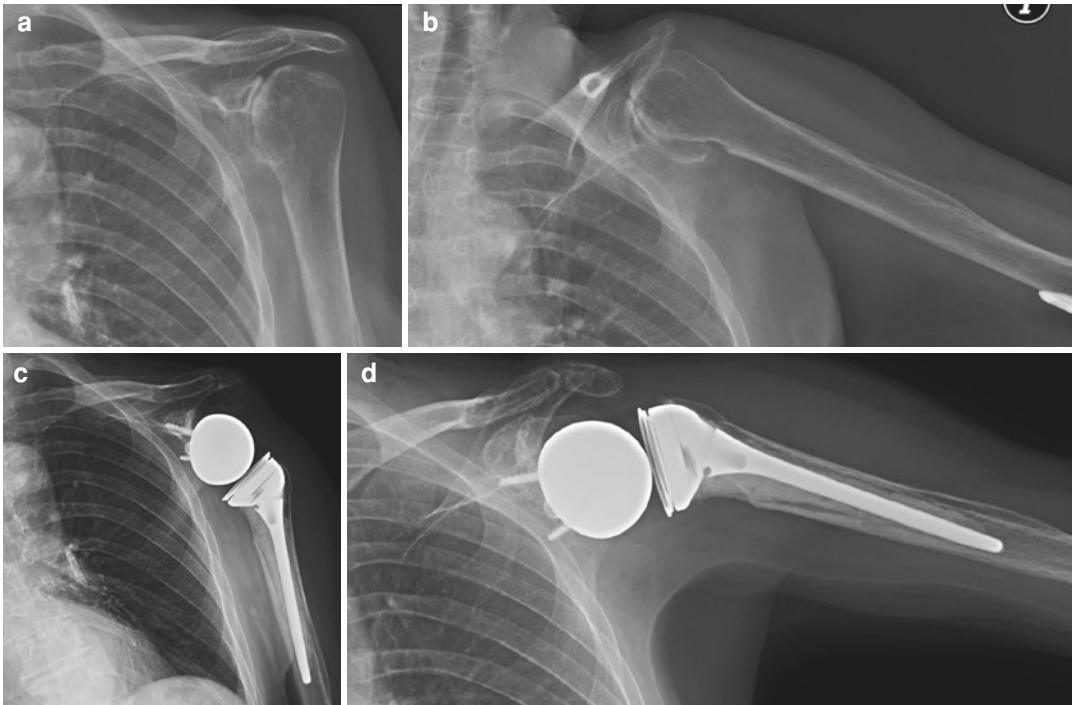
An 80-year-old woman presented with severe shoulder pain and disability. X-ray images showed a characteristic rotator cuff arthropathy with degenerative
